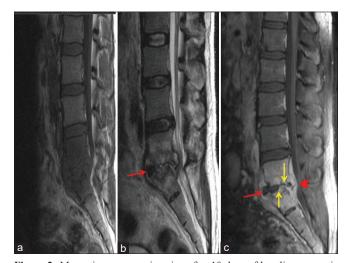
Magnetic resonance imaging after 10 days of baseline magnetic resonance imaging: (a) T1 sagittal, (b) T2 sagittal, (c) postcontrast images: Show extensive destruction of L5-S1 intervertebral disc with reduced disc height. The yellow arrows show an increase in the irregularity of the subjacent end plates with postcontrast enhancement. The red arrows show the anterior epidural soft-tissue component measuring 9.5 mm × 50 mm (anteroposterior × craniocaudal) indenting the cauda equina is seen (the red arrowhead)
